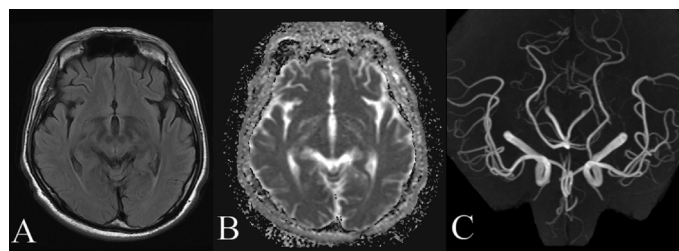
Magnetic resonance images on the 13th day
